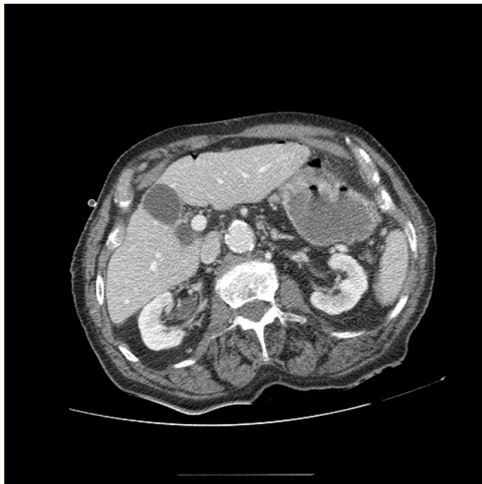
Axial view of CT scan.
